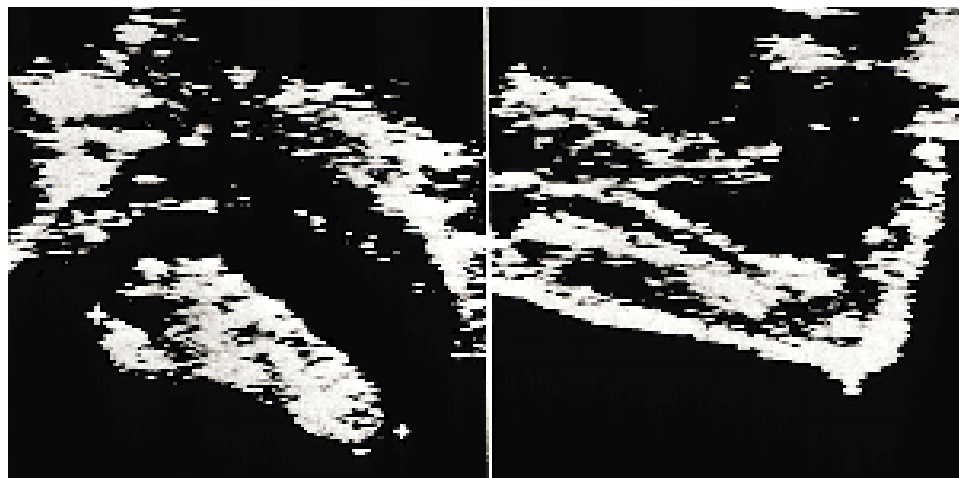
A prenatal ultrasound examination showing a view of a foot. Foot length on prenatal ultrasound has been shown to correlate well with gestational age.
